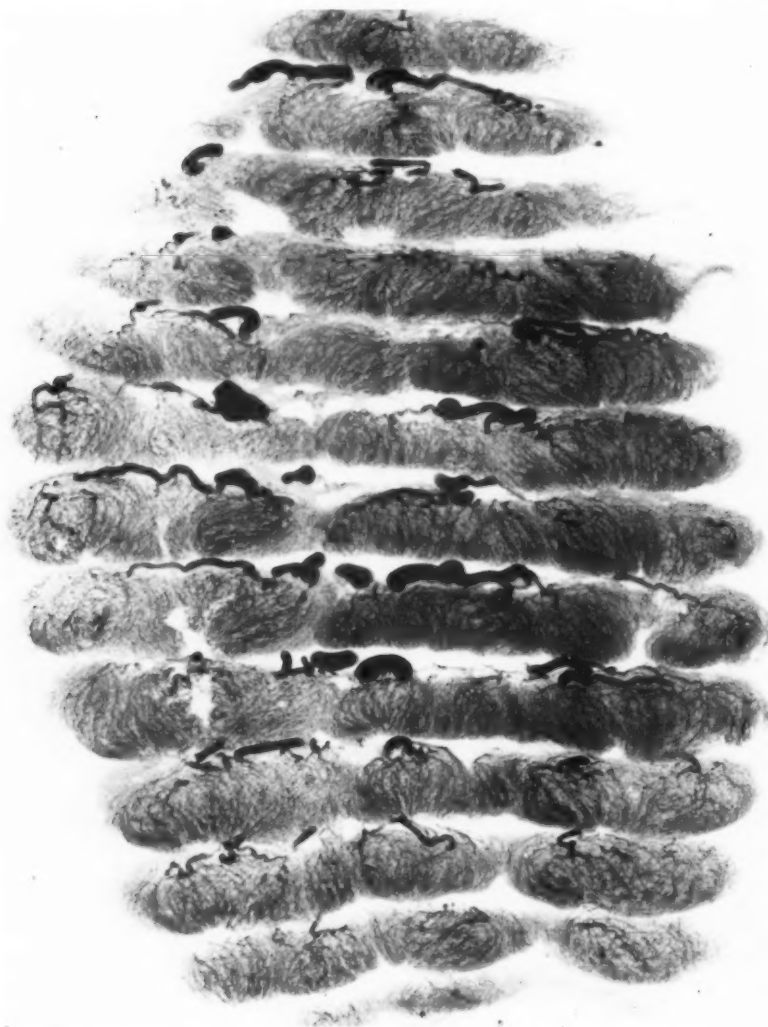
Roentgenogram of cross-section strips of placenta. No measurable circulatory arrest due to infarct formation.
